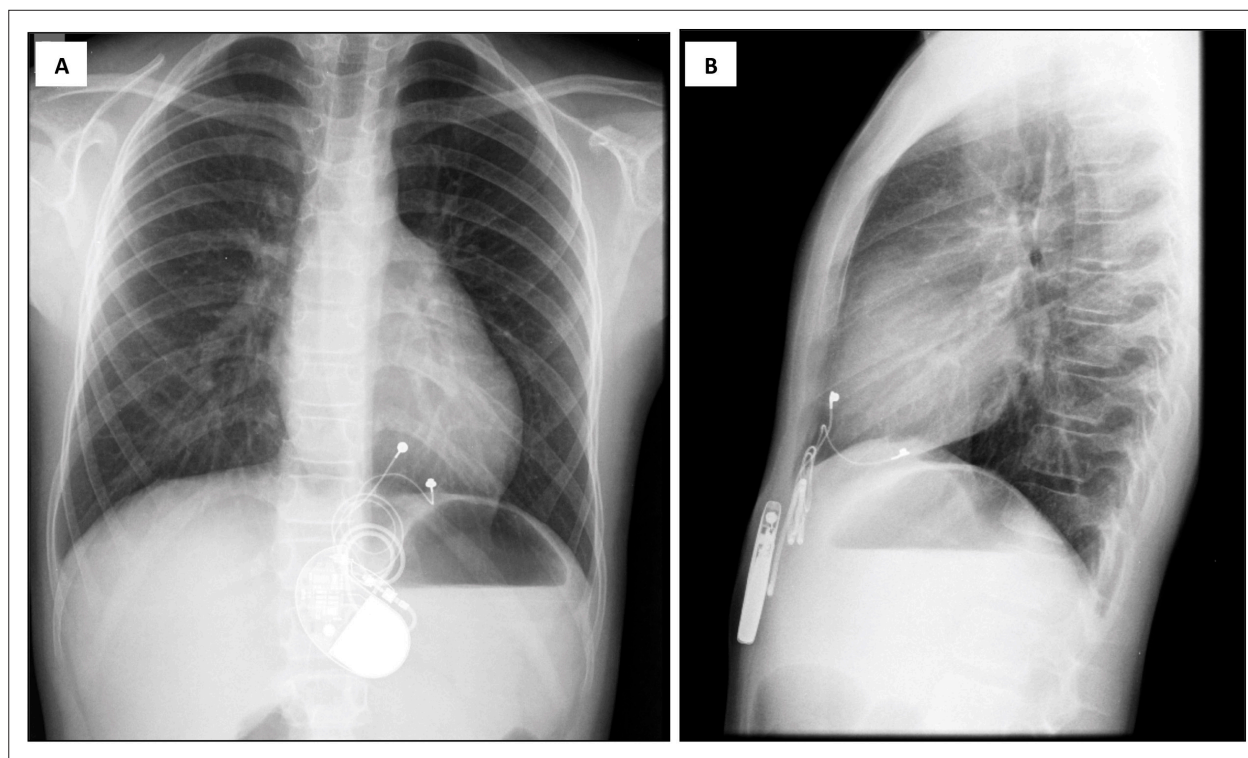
Chest radiographic projections displaying the appearance of epicardial pacemaker 10 years later, in anteroposterior (A) and lateral projections (B).
